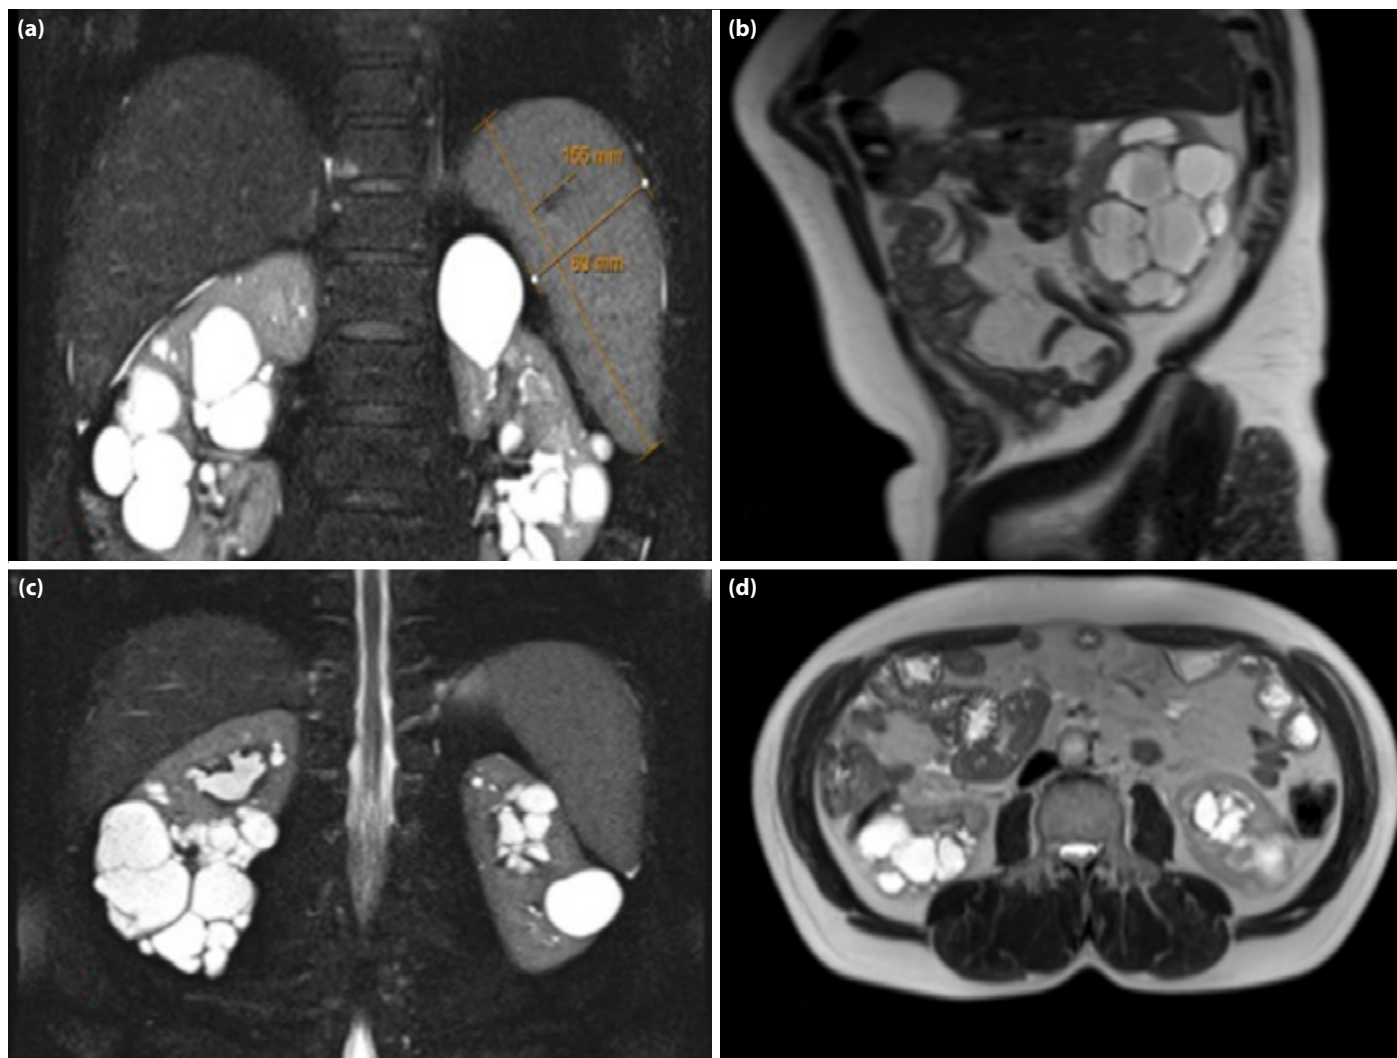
(a) Coronal T2-weighted magnetic resonance (MR) image showing splenomegaly, with the spleen measuring approximately 155 mm in craniocaudal and 69 mm in anteroposterior diameter. The enlarged spleen is consistent with hypersplenism observed in the patient. (b) Sagittal T2-weighted MR image demonstrating multiple well-defined cortical cysts in the left kidney, consistent with a polycystic kidney disease-like phenotype. The cysts vary in size and show homogeneous hyperintense signal characteristics. (c) Coronal T2-weighted MR image revealing multiple bilateral cortical and medullary cysts of varying sizes in both kidneys, consistent with a polycystic kidney disease-like phenotype. The renal parenchyma between the cysts appears thinned. (d) Axial T2-weighted MR image demonstrating multiple bilateral renal cortical cysts of varying sizes, compatible with a polycystic kidney disease-like morphology. The cysts exhibit high signal intensity, and the intervening parenchyma shows mild thinning.
